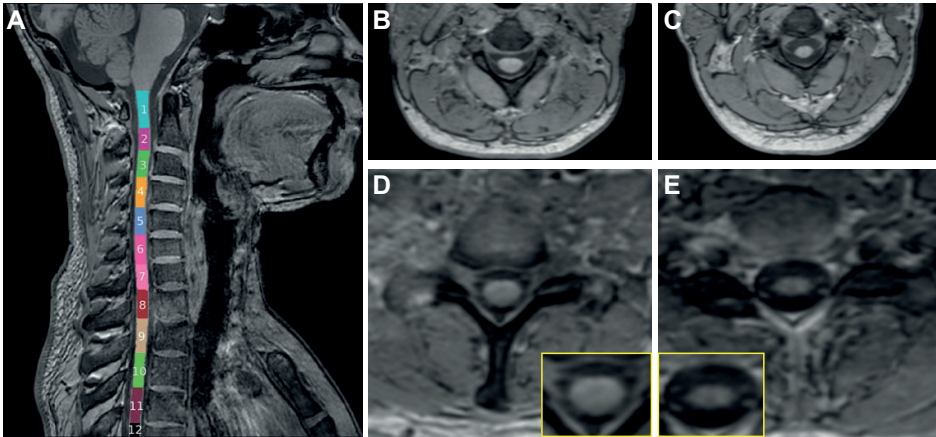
Example of MR images
